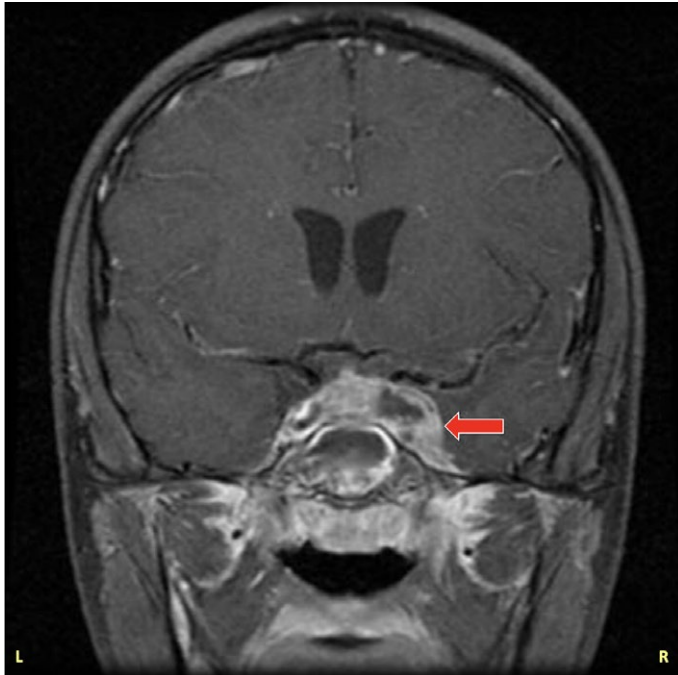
Magnetic resonance imaging of the skull showing thickening of the cavernous sinus with visualization of hyperintense tissue, especially on the right side, compatible with cavernous sinus thrombosis.
